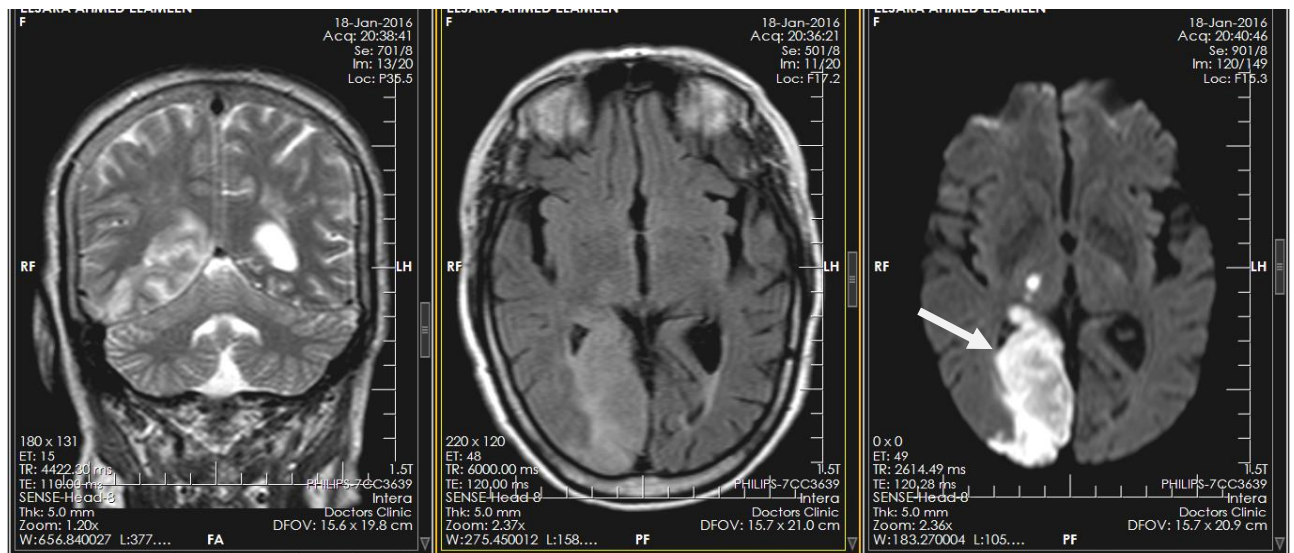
Coronal T2, axial FLAIR and DWI showing right occipital and thalamus recent acute infarctions for male patient 60years old.
